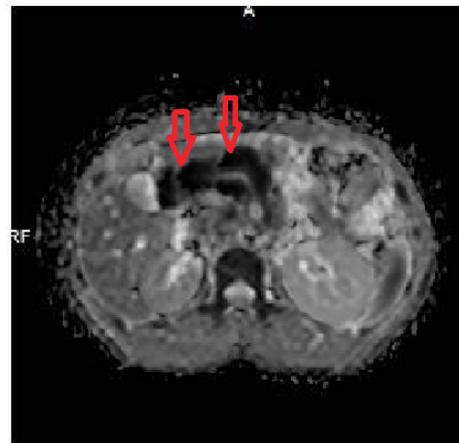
The mass regarded a significant diffusion restrictions on DWI and ADC-maps.
